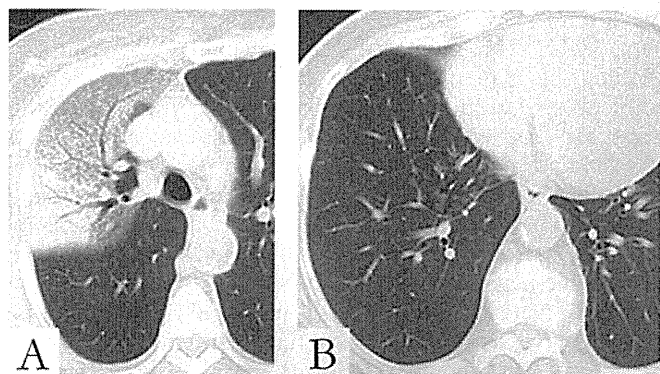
CT of nonmucinous lepidic predominant adenocarcinoma. CT images show (*A*) predominantly GGO in the right upper lobe and (*B*) multiple GGN in the right lower lobe. CT, computed tomography; GGN, ground-glass nodule.
